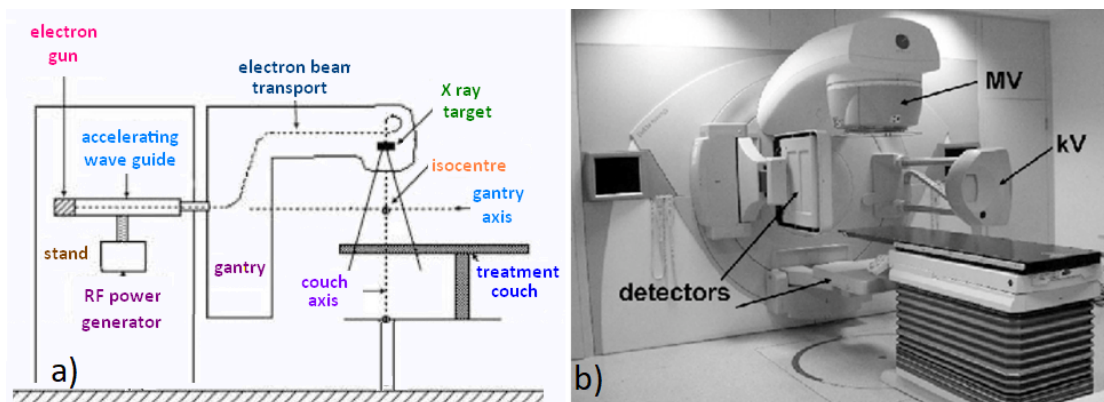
a) LINAC component b) Elekta Synergy with a foldout MV-detector (iViewGT) and a kV-CBCT system (XVI). (Figures from [56])
